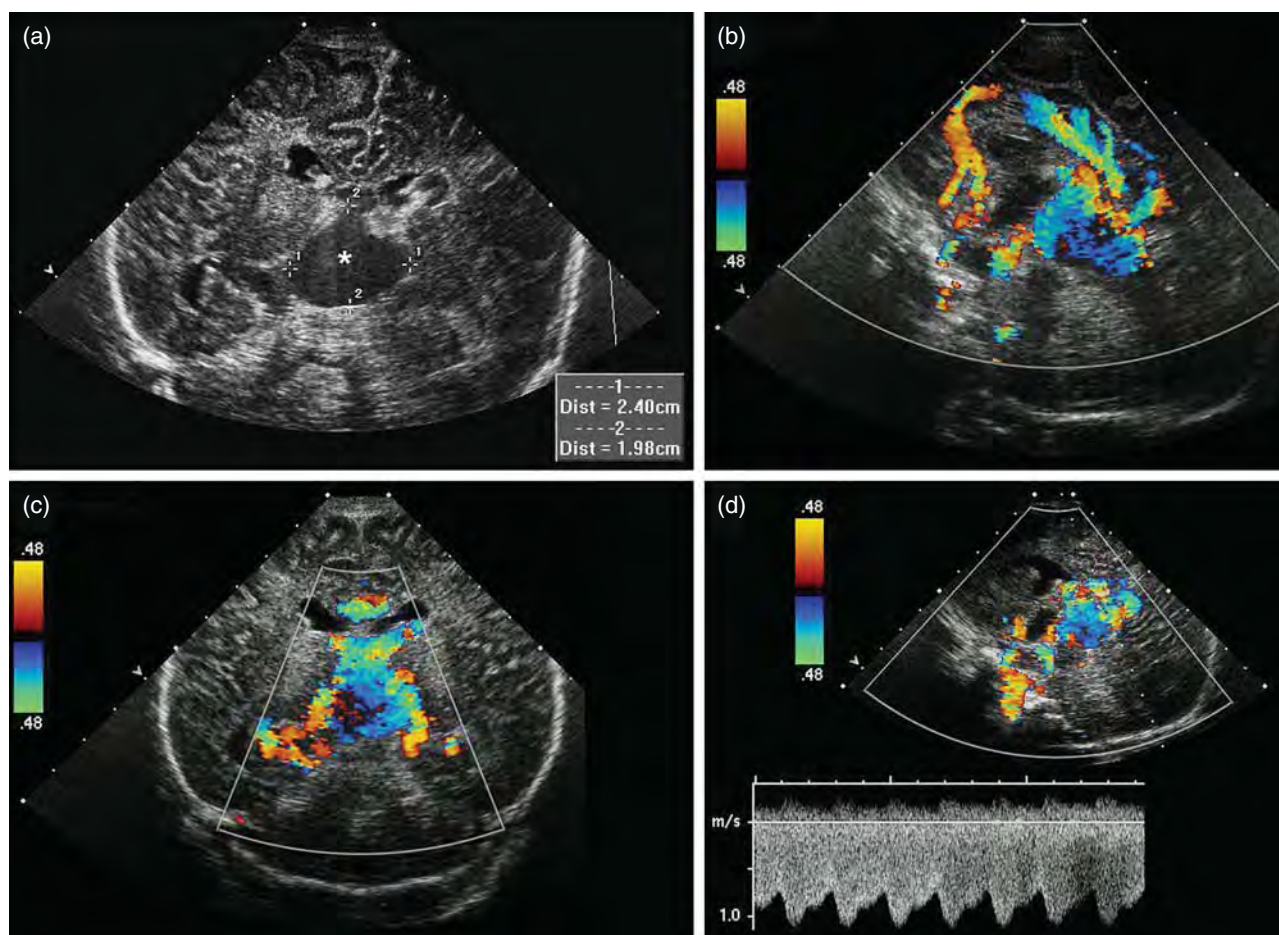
Neonate with large vein of Galen aneurysmal malformation (VGAM). (a) Coronal plane image depicting a dilated hypoechoic vascular structure (asterisk shows prosencephalic vein). (b) Sagittal plane image with color Doppler demonstrating increased vascular flow through multiple paramedian vessels. (c) Coronal plane image of structures depicted in (b). (d) Doppler interrogation shows continuous flow in the dilated vascular structures, consistent with a large VGAM.
